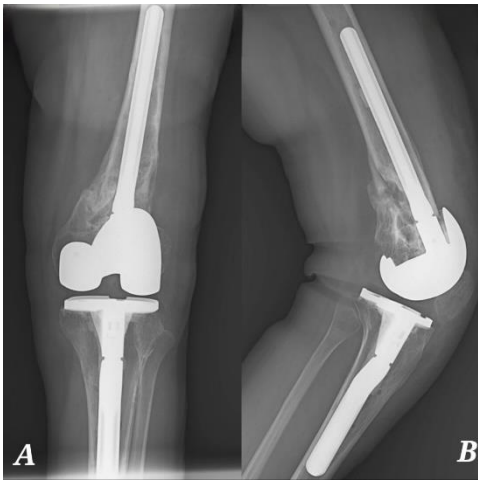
Post Operative radiography shows NexGen legacy Constrained Condylar Knee (LCKK) system with femoral and tibial stem and PS polyethylene A: Anter-posterior view B: Lateral view
